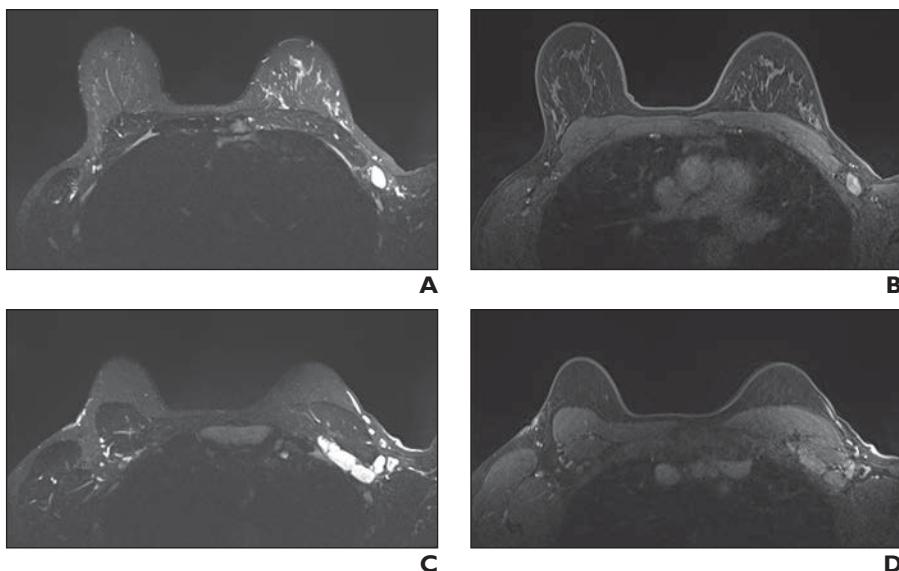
33-year-old woman who underwent diagnostic follow-up breast MRI 16 days after COVID-19 vaccination.
